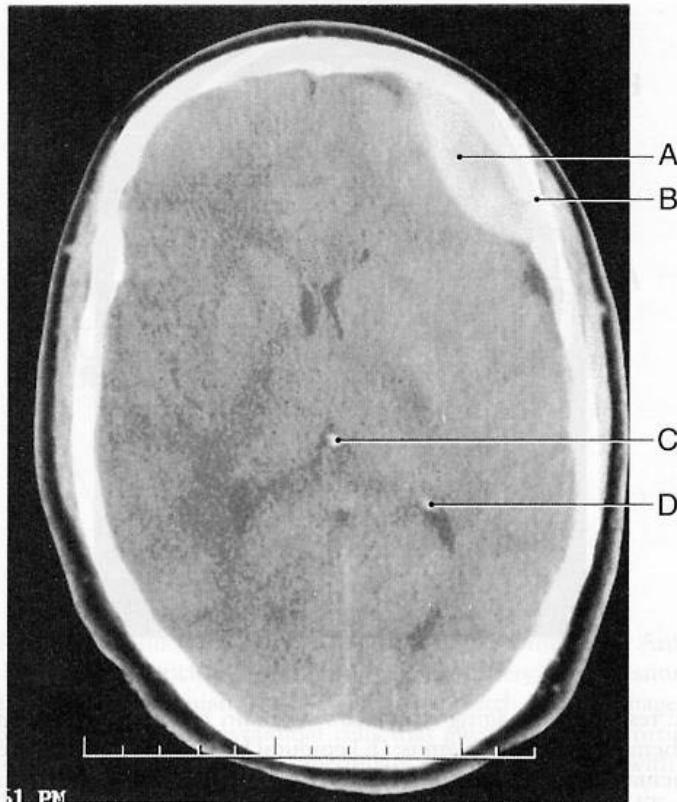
Computed tomography axial section showing an epidural hematoma and a skull fracture. (A) Epidural hematoma; (B) skull fracture; (C) calcified pineal gland; (D) calcified glomus in the trigone region of the lateral ventricle. The epidural hematoma is a classic biconvex, or lentiform, shape.
